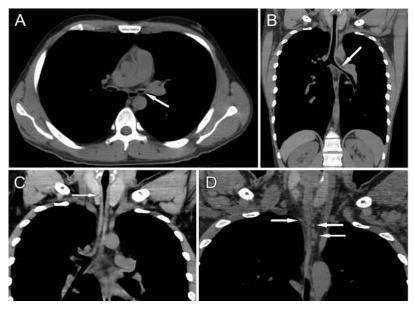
Horizontal (A) and coronal (B) sections of a thoracic computed tomography scan revealed diffused thickening of the anterior and lateral walls with posterior wall spared, involving trachea, bilateral main bronchi, and right intermediate bronchus. Note the high-grade obstruction of the left main bronchus (white arrows). Airway wall calcification (C) and mediastinal lymph nodes with the largest diameter of 6 mm (D) are indicated by white arrows.
